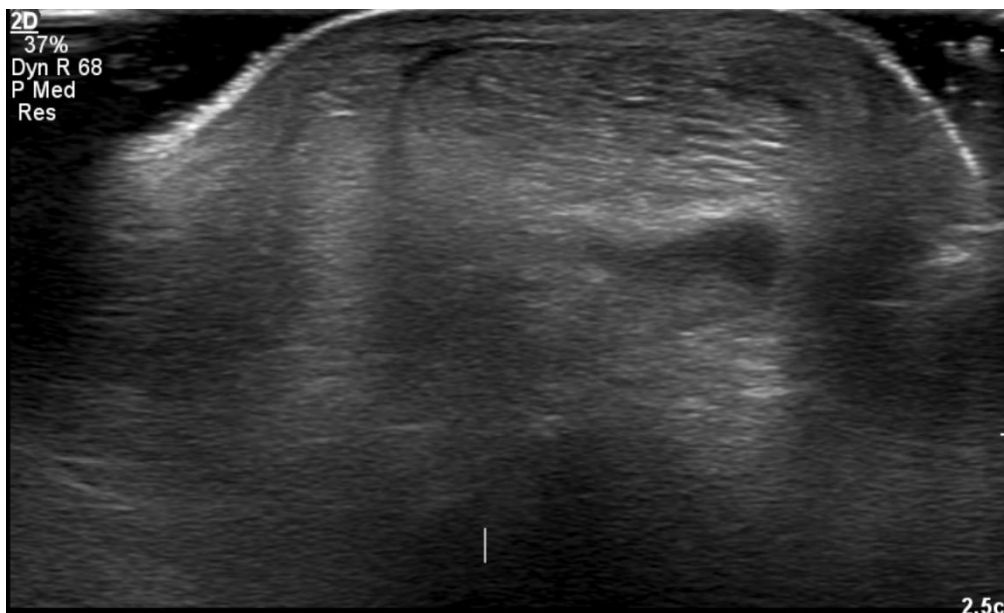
52 yrs old female patient with rheumatoid arthritis complaining of morning stiffness and limitation of movements of her hand showing 3.A. STIR MRI axial image showing Mild tenosynovitis of extensor digitorum and extensor indices proprius tendons. B. Ultrasound transverse view showing mild tenosynovitis of 4th compartment tendons (extensor digitorum and extensor indices prop. Tendons).
